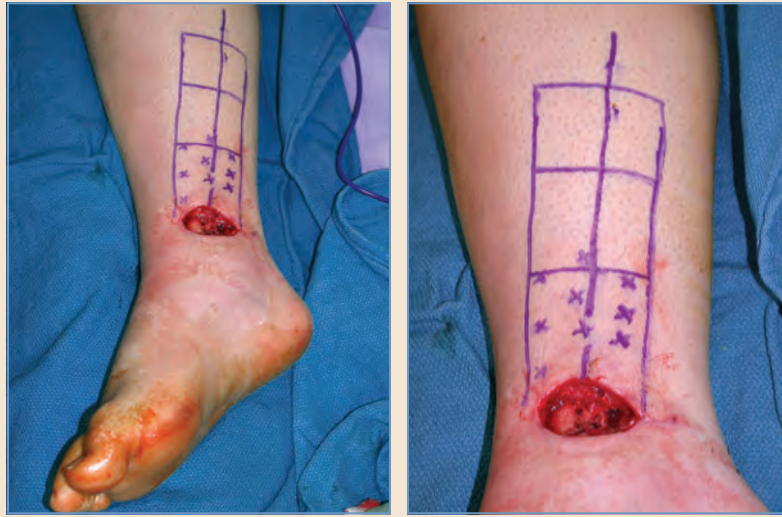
Design of an adipofascial turnover flap. A handheld Doppler probe is used to identify perforating vessels, and the flap base is centered over this area. The total flap length is three times the length of the defect to be covered. The distal third covers the defect, the middle third is folded on itself, and the proximal third is the flap base. The fascia and fat of the flap are dissected from the overlying skin and underlying muscle. The skin is closed primarily, and the flap is covered with a skin graft. (Courtesy of Michael L. Bentz, MD.)
